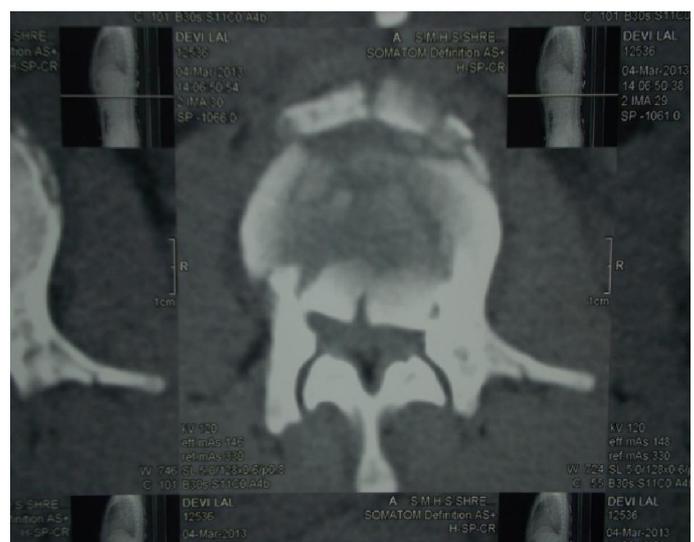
CT-scan axial view showing burst fracture
